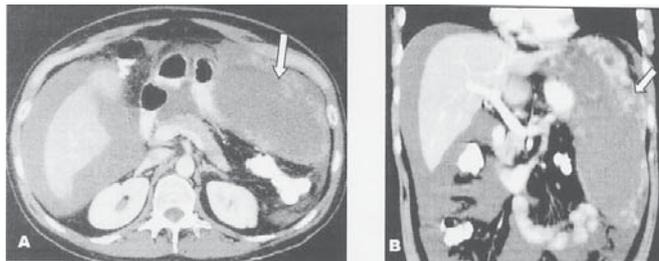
Multislice computed tomography demonstrating a large gastric tumor lesion (arrows), which is heterogeneous, with hypodense areas confirmed as myxoid degeneration areas in GIST, and observed in axial section (A) and coronal reconstruction (B). Note: presence of ascites
